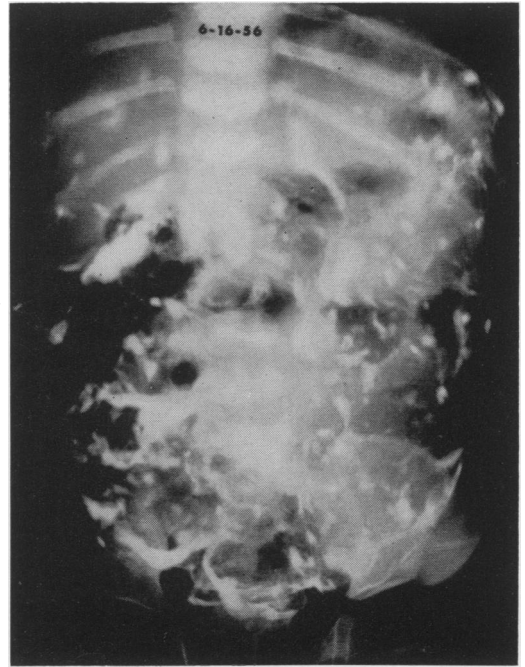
Abdominal x-ray at time of re-admission because of pain and vomiting, case #2.
